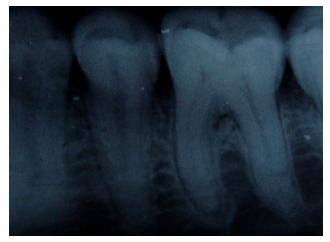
Radiograph showing widening of periodontal ligament space
